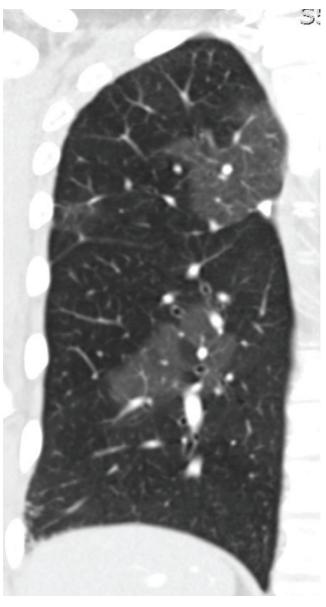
CT of the right lung showing a mosaic pattern, depicting areas of hypoperfusion and hyperperfusion
